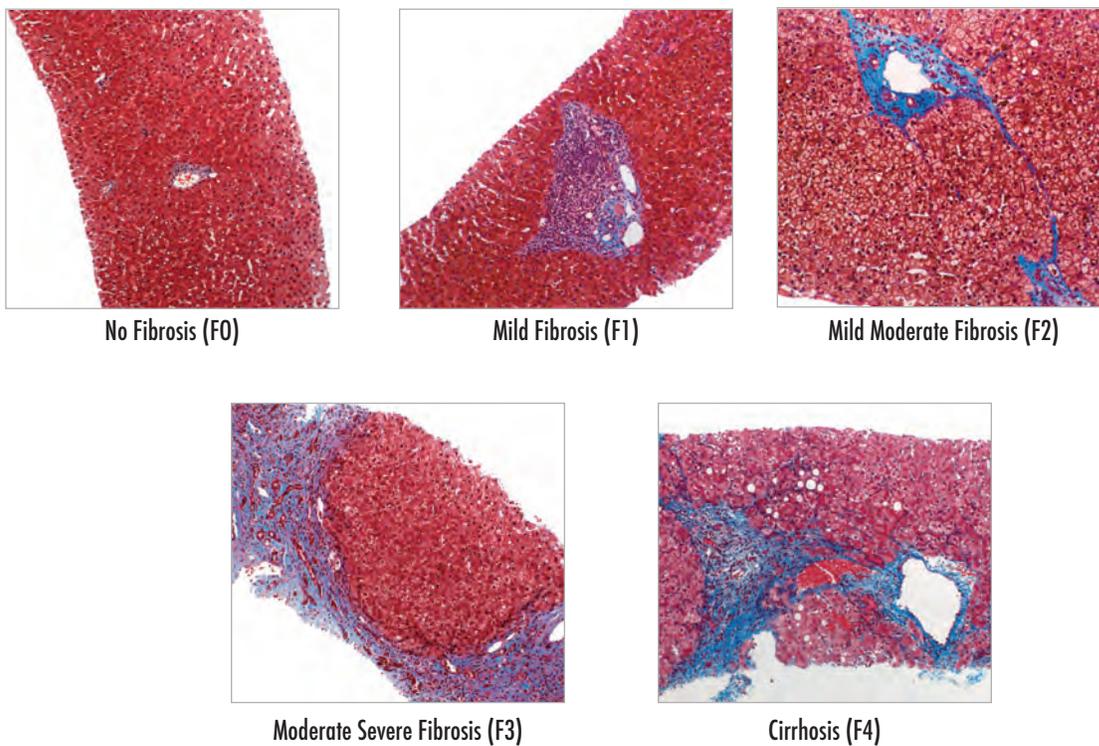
shows the progression of liver scarring, or fibrosis. The white splotches surrounded by blue and the darkened coloring show increases in scarring, notably around the arteries and veins in the liver. Stage F3 indicates significant inflammation around the central veins and tiny connective tissue. Stage 4 cirrhosis, or chronic liver disease, shows thickening of the tissue and loss of the ability to produce certain proteins and process nutrients, medications, and toxins. Source: Faria SC, Ganesan K, Mwangi I, et al. MR imaging of liver fibrosis: Current state of the art. *Radiographics* 2009; 29:1615-35.
